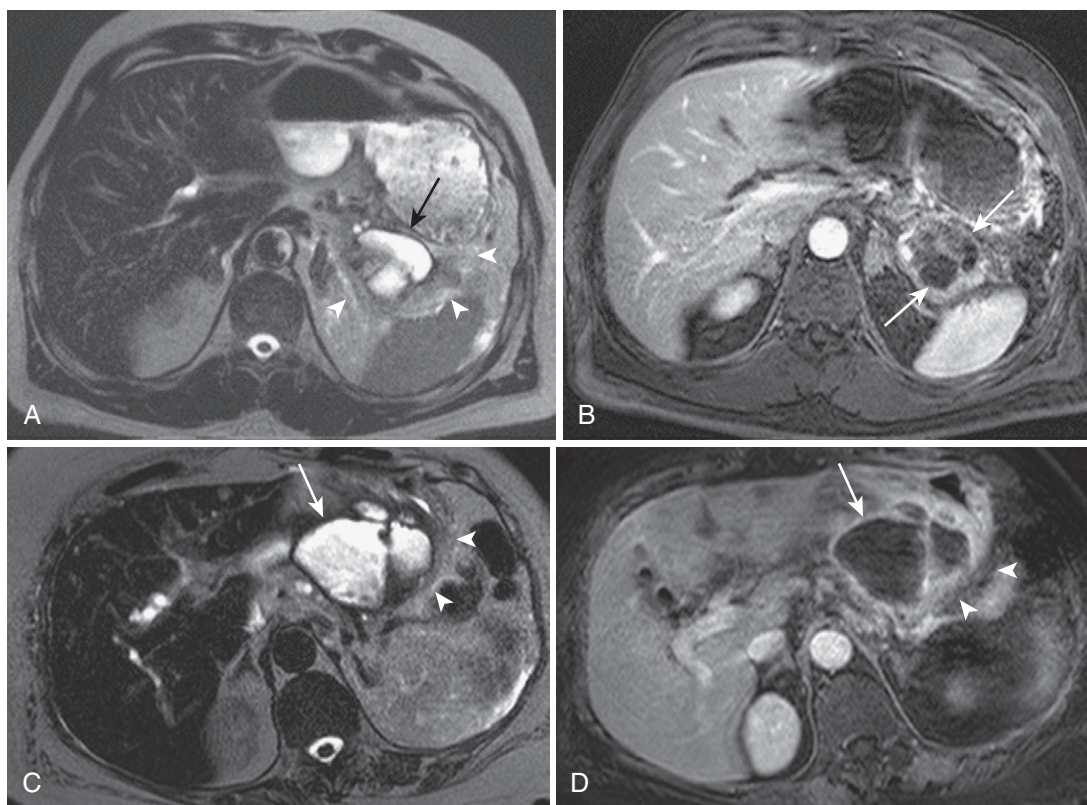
Pancreatic pseudocysts. A, Heavily T2-weighted image shows an irregularly shaped, septated pseudocyst in the pancreatic tail (*arrow*), which is surrounded by edema (*arrowheads*). B, The postcontrast image demonstrates absent enhancement in the locules (*arrows*). In a different patient with pancreatitis, the heavily T2-weighted (C) and postcontrast (D) images reveal a large, complex, multiloculated pseudocyst (*arrow*) abutting the lesser curvature of the stomach. Mild surrounding edema and inflammation (*arrowheads*) and a history of pancreatitis help confirm the etiology and exclude neoplastic lesions.
